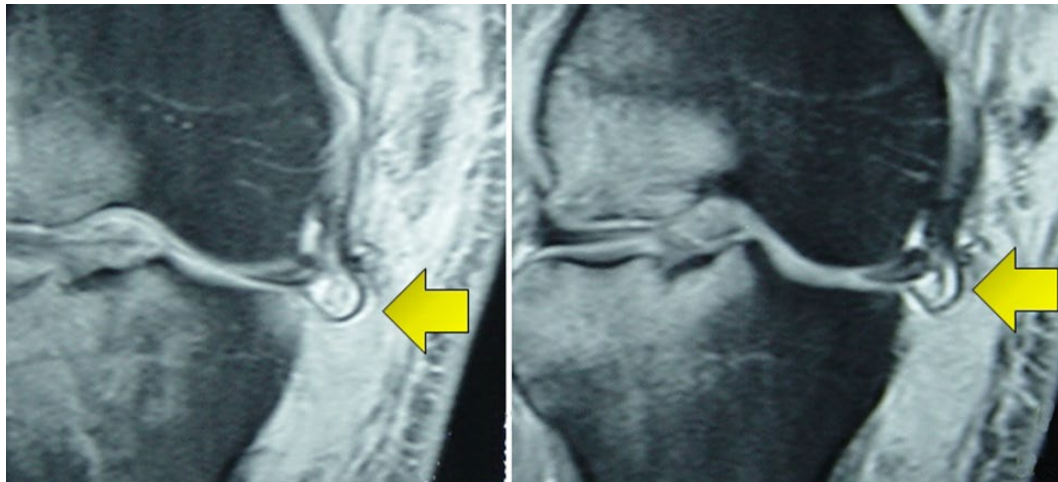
Coronal MR images of interposition of the distal MCL under the medial meniscus after being torn from the tibial attachment. Widespread bone bruising in the lateral compartment indicates the severity of valgus injury.
